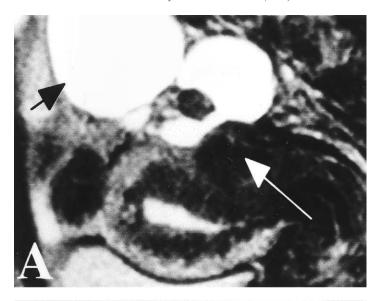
(A) T2-weighted uterine MR scan demonstrates that multiple pelvic endometriotic lesions are visible, such as large ovarian endometriomatas (*black arrow*) and deep rectovaginal endometriosis (*long white arrow*). (B) Axial T1-weighted image obtained with a fat-saturation technique shows a small, hyperintense lesion surrounding the left ureter at the site of obstruction (*arrow*). The hyperintense lesion represents a blood clot, which corresponds to a small endometrioma.
